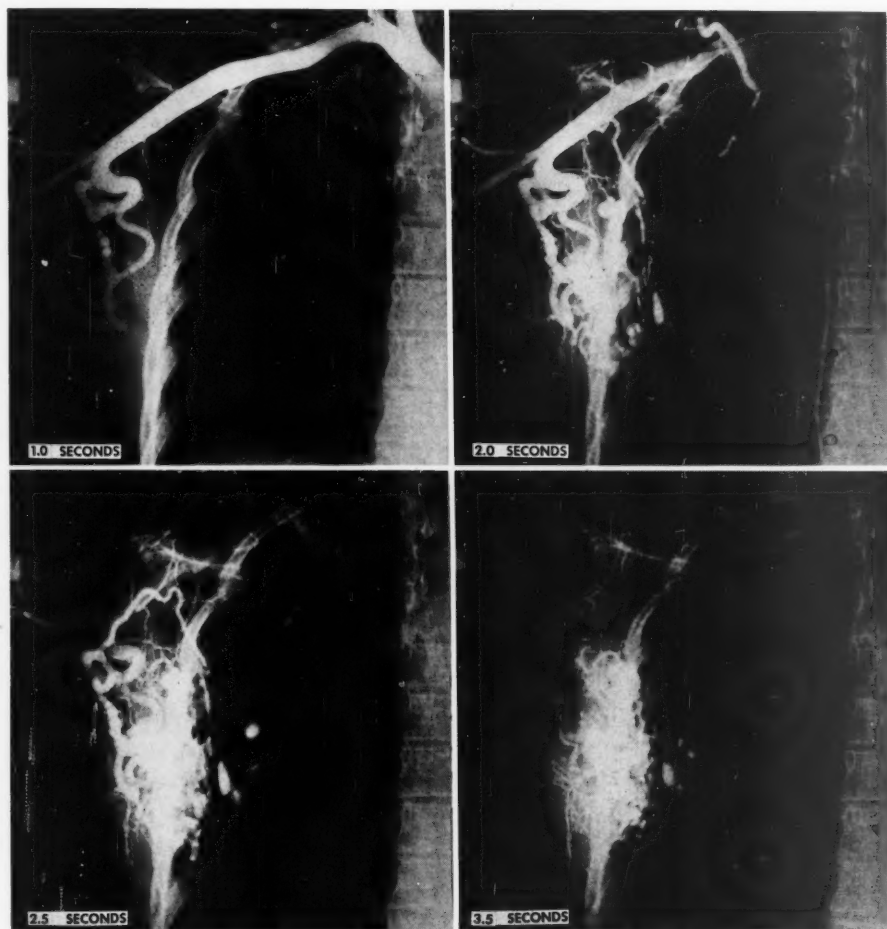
Congenital Arteriovenous Fistula, Right Scapula (Retrograde Peripheral Arteriogram)*. 22 year old female (N.Y.H. 572 681). Polyethylene tubing inserted into brachial artery at antecubital fossa and passed proximally for five inches. Forty-five cc. of 75 per cent Neo-iopax were injected during one second, roentgen exposures being made every half second during and for 10 seconds following the injection. Films selected from series show complex arteriovenous fistula filling from numerous arteries arising from axillary, subclavian and transverse scapular arteries. Delineation of lesions facilitates surgical treatment.
